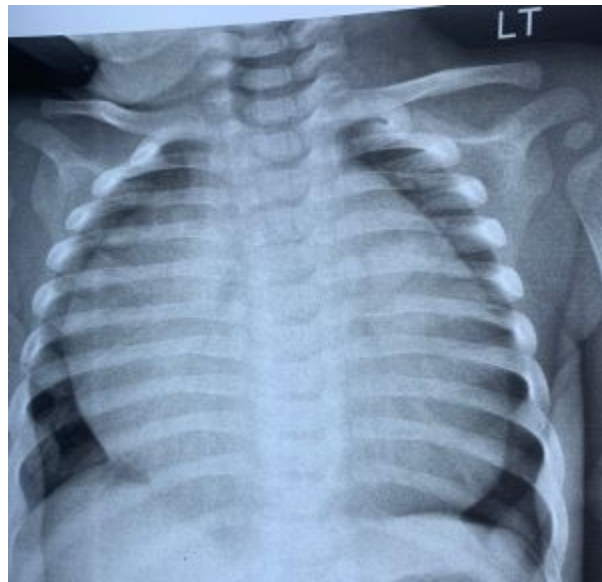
Chest x-ray showing a globular heart
